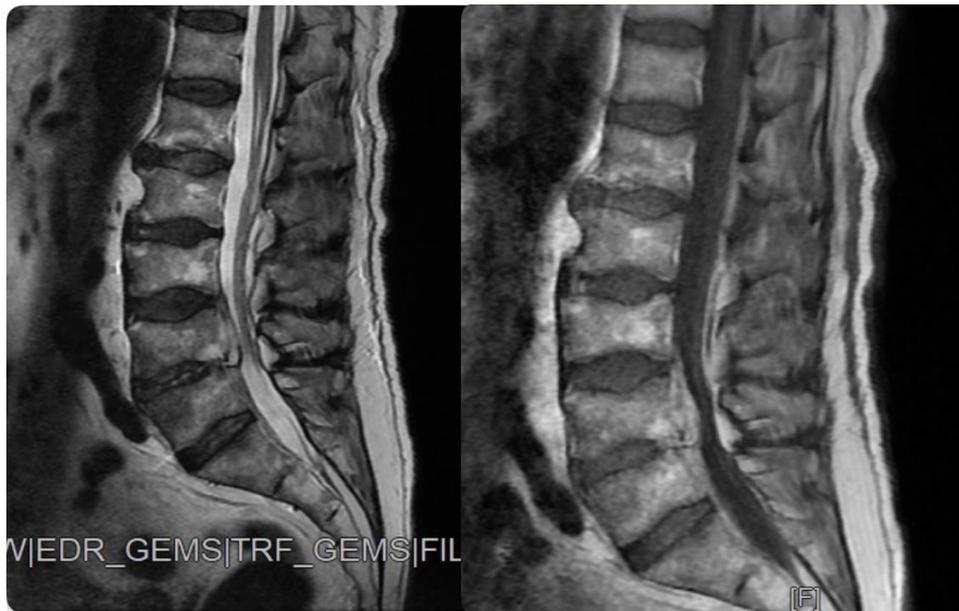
A. MRI T2 sequence, no iv contrast- Decrease in size of both the epidural collection, especially the posterior one.
